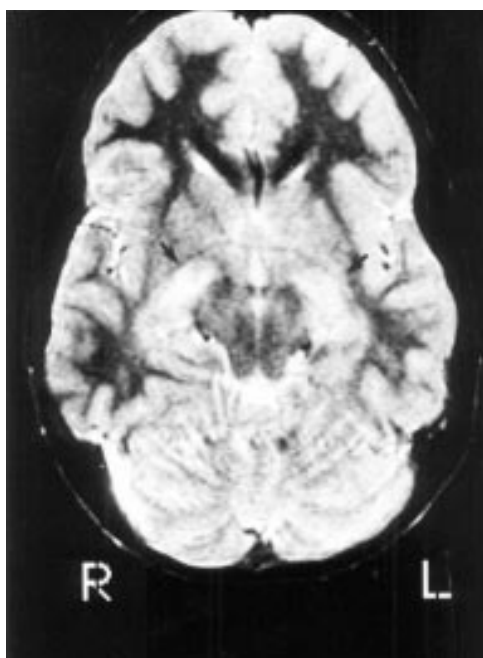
MRI, axial cut, T2 weighted (2800/90). Hyperintense signal is noted in the visual pathways on both sides (arrows), indicative of infiltration by the optic glioma.
